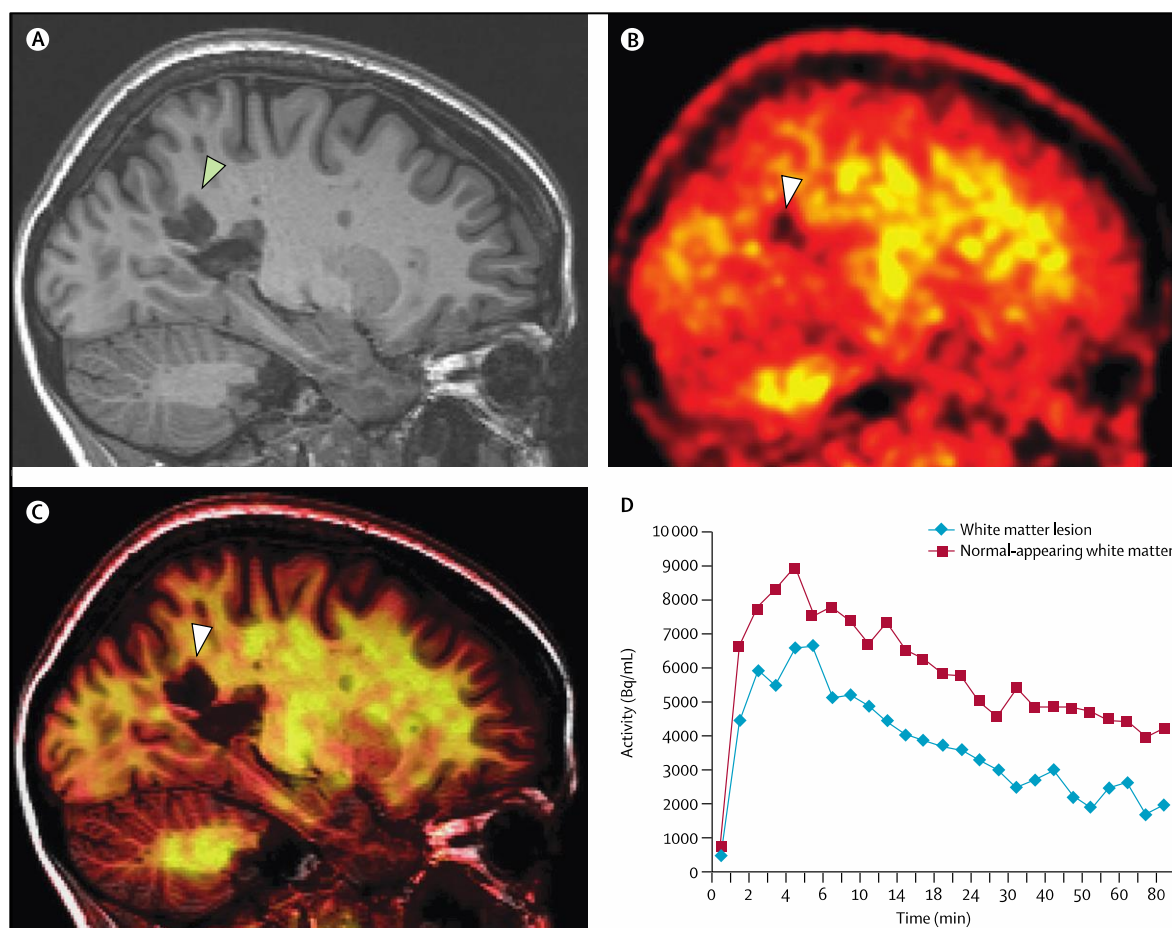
[11C]PIB in MS. The uptake of [11C]PIB is lower in MS lesions compared with normal-appearing white matter in patients with MS, suggesting the presence of demyelination. (A) T1-weighted image and (B) corresponding map of [11C]PIB PET binding in a patient with MS, showing lower [11C]PIB uptake in the GM in general compared with WM and lower uptake in a MS lesion (arrow head) compared to normal-appearing WM. (C) Coregistration of images shown in (A) and (B). (D) Time–activity curve of the normal-appearing WM (red) and the lesion seen in (A) (blue). PIB=thioflavine-T derivative 2-(40-methylaminophenyl)-6-hydroxybenzothiazole.
